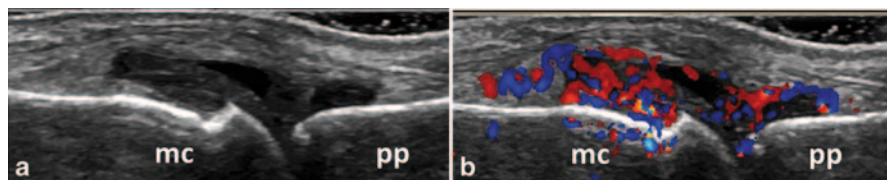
Longitudinal view of the dorsal aspect of the metacarpophalangeal joint showing B-mode synovitis (a) with Doppler signal (b); *mc* metacarpal head; *pp* proximal phalanx
